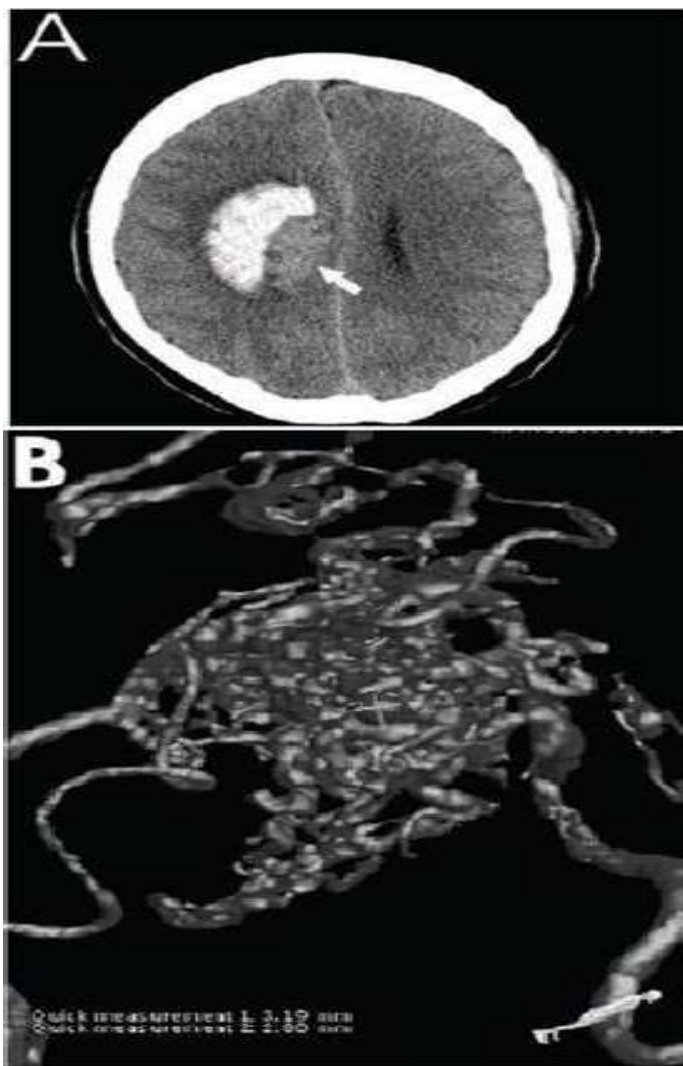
A. CT scan of right-side ICH caused by AVM in a 44-year-old male. AVM is visible even in the plain CT scan (white arrow). B. 3D-DSA of the aneurysm with a small secondary aneurysm. (Source: Report of patient admitted in Department of Neurology, Narayana Medical College & Hospital, Nellore, A.P., and India).
